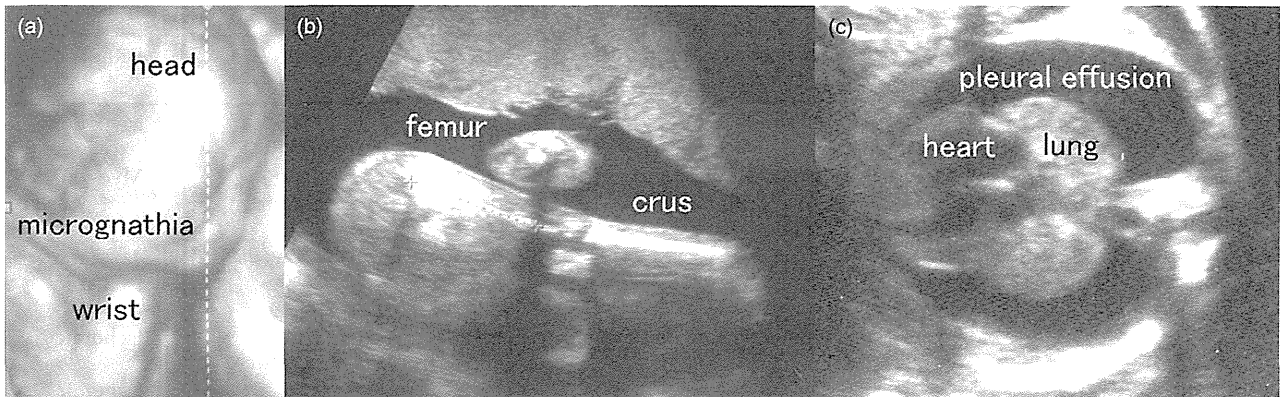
Ultrasonographic images of the twin A fetus showing (a) severe micrognathia and flexed wrists, (b) extended legs, and (c) pleural effusions.
